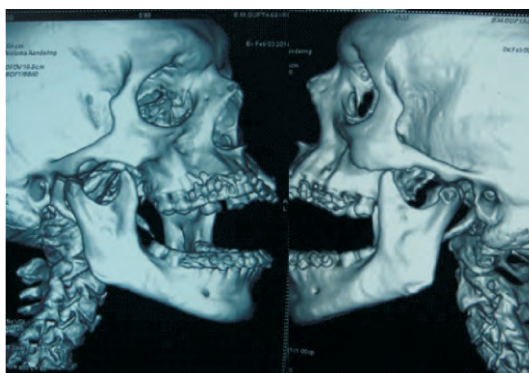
a : Pre-op 3-D CT revealing no sign of condylar pathology and articular eminence in normal limit.
